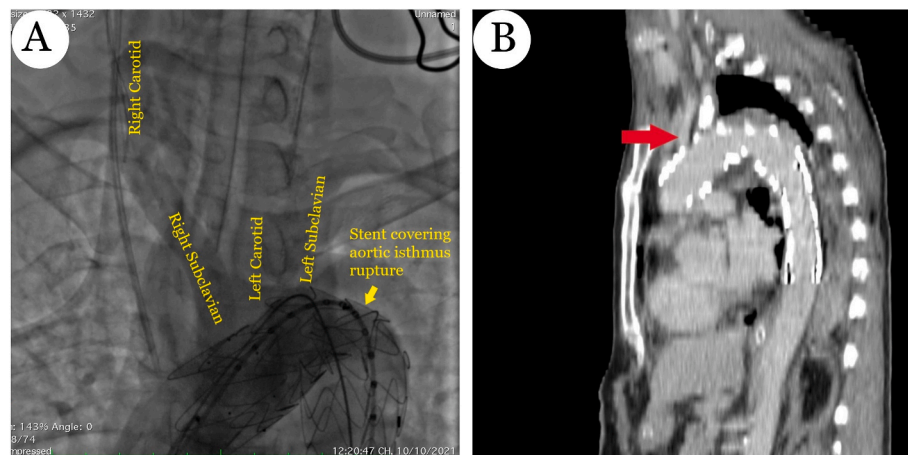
Stent covering aortic rupture on C-arm imaging (A) and computed tomography of the fourth day (B).
